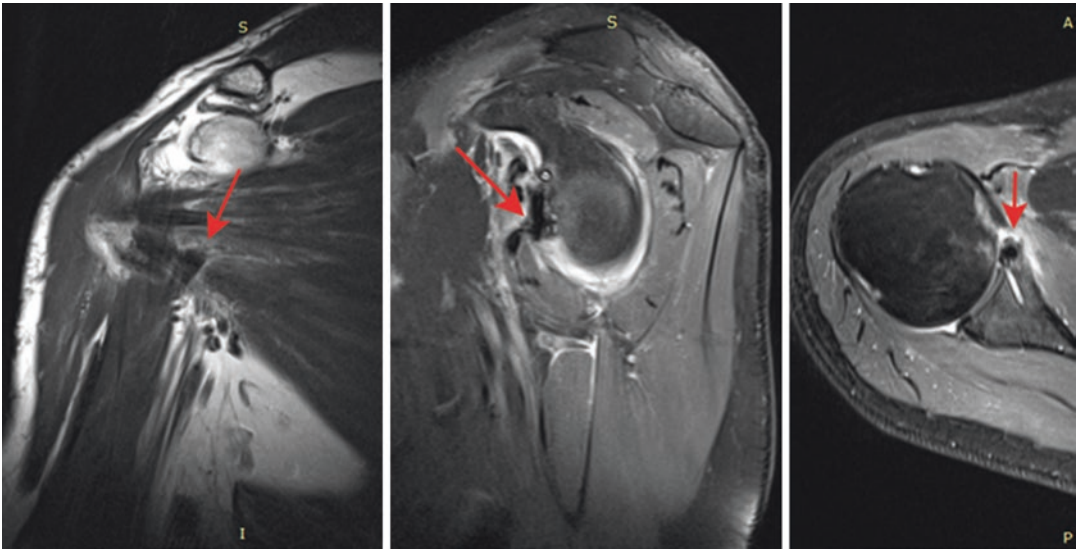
View of MRI 6 months after the surgery. The arrow shows long head of biceps graft
